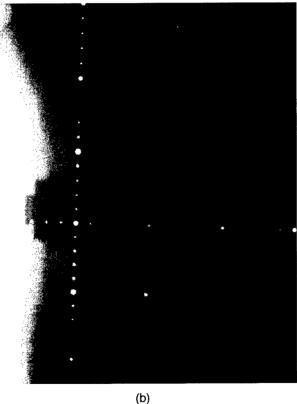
(a) Right anterior oblique digital reconstructed radiograph. (b) Right anterior oblique port film.
